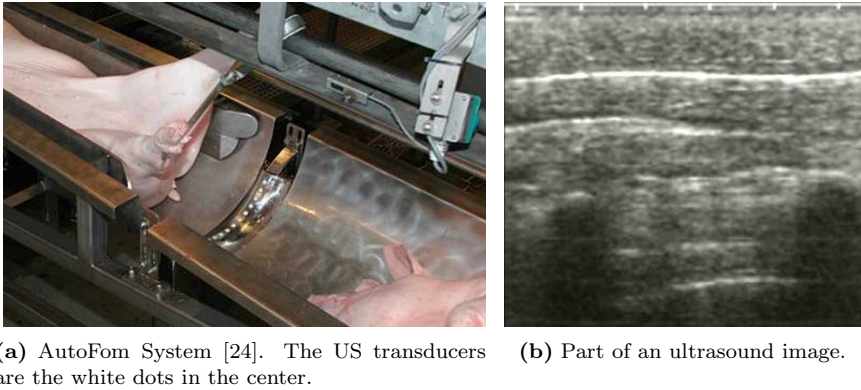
Measuring fat thickness using ultrasound. The shadows in (b) are due to two ribs which reflect most of the signal. (Courtesy of DMA).
